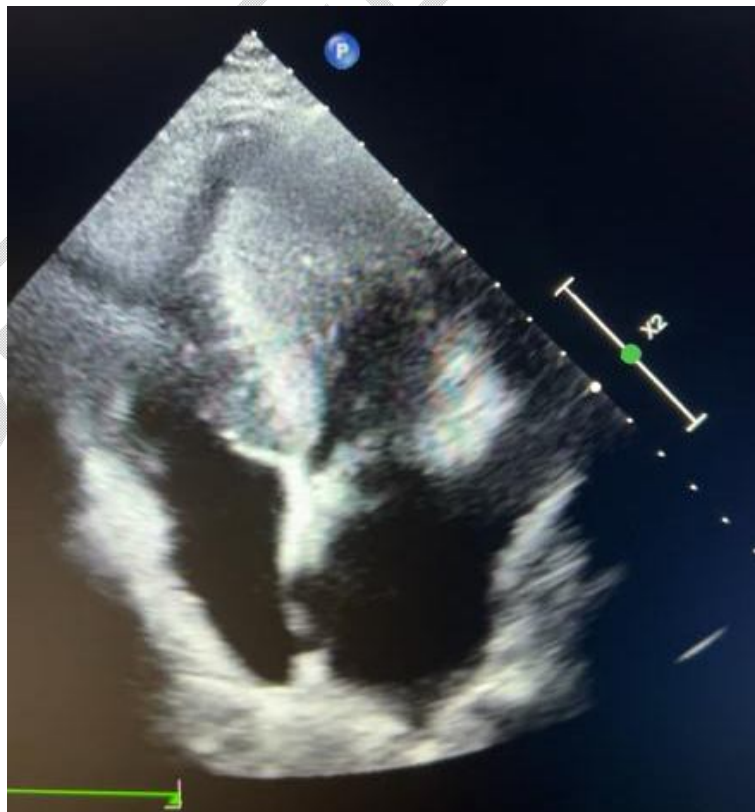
Four-cavity echocardiographic image after 7 days of anticoagulation showing the disappearance of the thrombus
